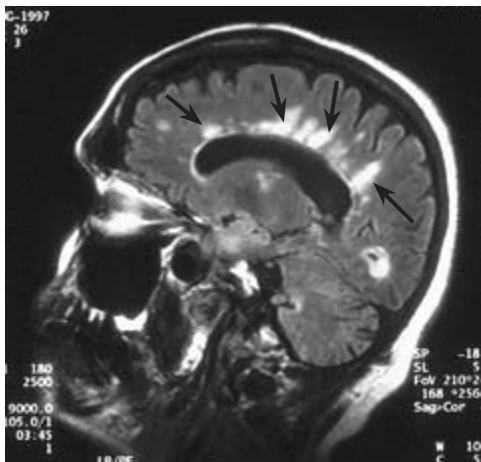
FLAIR sequence image of a sagittal section from the brain of a patient with MS. Multiple high-signal white lesions (arrows) radiate from the surface of the lateral ventricles.
